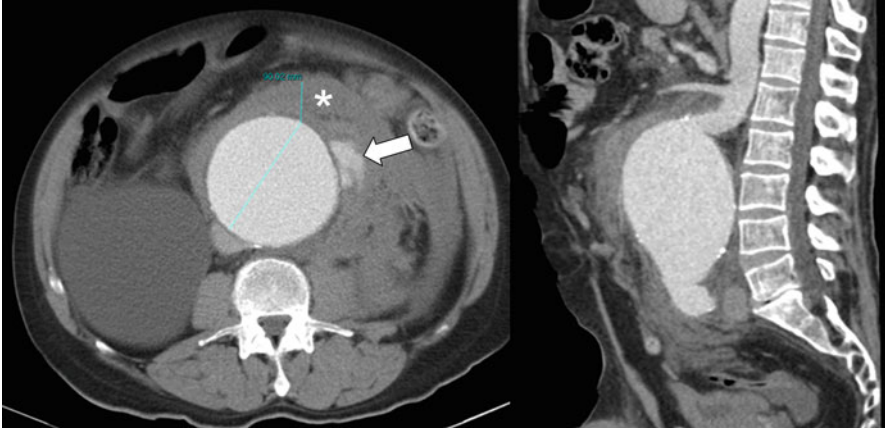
CT Angiogram of a 72-year-old man with 9 cm ruptured abdominal aortic aneurysm with active extravasation (*arrow*) and retroperitoneal hematoma (*asterisk*) in axial (*left*) and sagittal (*right*) planes
